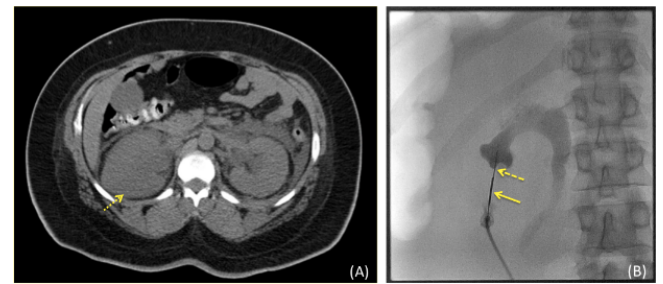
Patient 3 Images. (A) CT-scan image demonstrating a distance of 12 cm from the skin to the kidney calyx indicative of a moderately obese patient. Fluid and blood can be seen surrounding the minimally-moderately dilated kidney (dotted arrow) from a previous failed attempted percutaneous nephrostomy at an outside hospital. (B) Fluoroscopy-saved Image of coaxial needle technique with 15 cm, 18 gauge trocar needle (solid arrow) resting against left kidney capsule and 20 cm, 22 gauge Chiba needle (dashed arrow) entering lower pole calyx.
